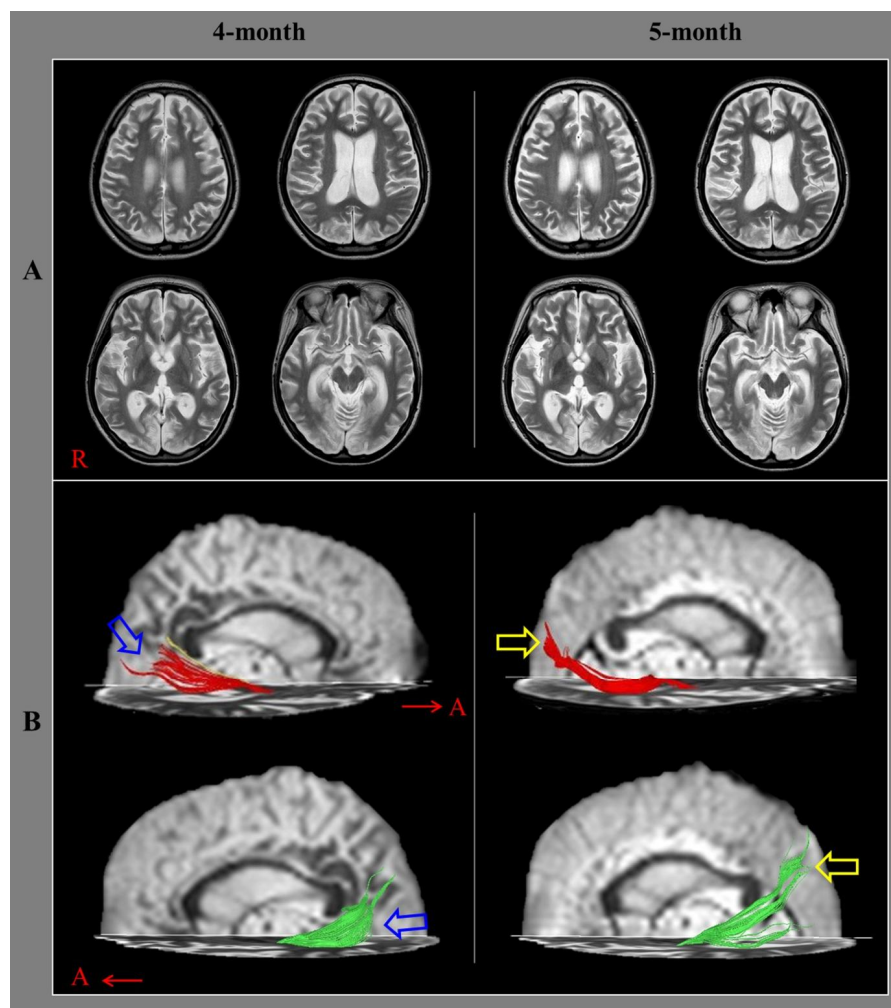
Brain magnetic resonance images at four and five months after onset showed leukomalactic lesions in the parieto-temporo-occipital lobes in both hemispheres. B: Results of diffusion tensor tractography (DTT) for optic radiation (OR). On 4-month DTT, discontinuations (blue arrows) except for tiny fibers in the posterior portions of the OR were observed in both hemispheres. However, the OR was connected to the upper occipital lobe on both sides (yellow arrows) on 5-month DTT.
